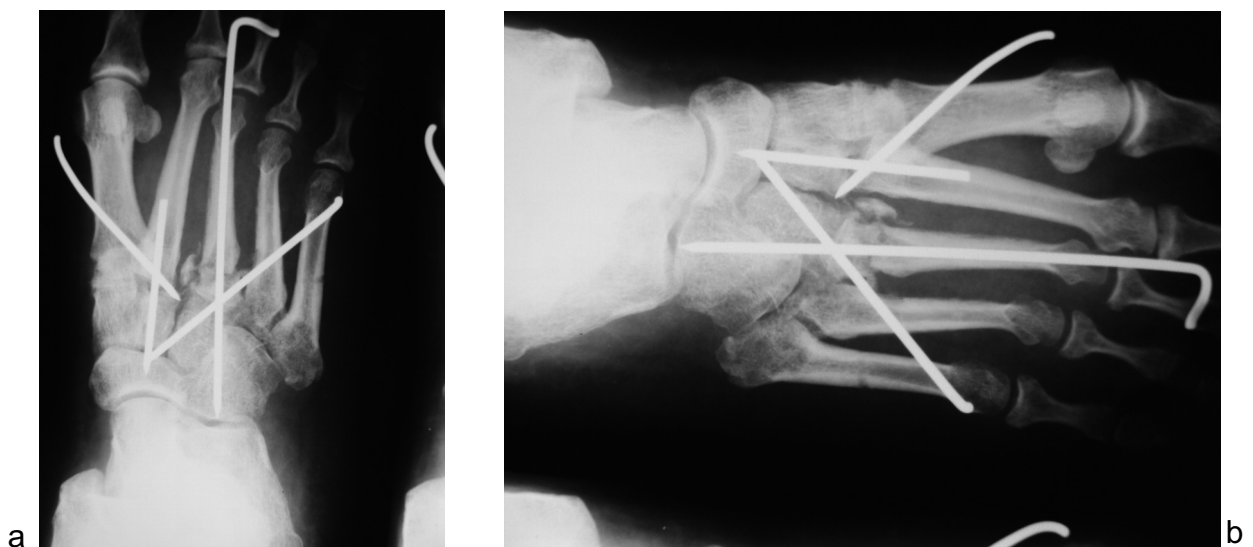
Anteroposterior (a) and medial oblique radiograph (b) at 8 weeks
